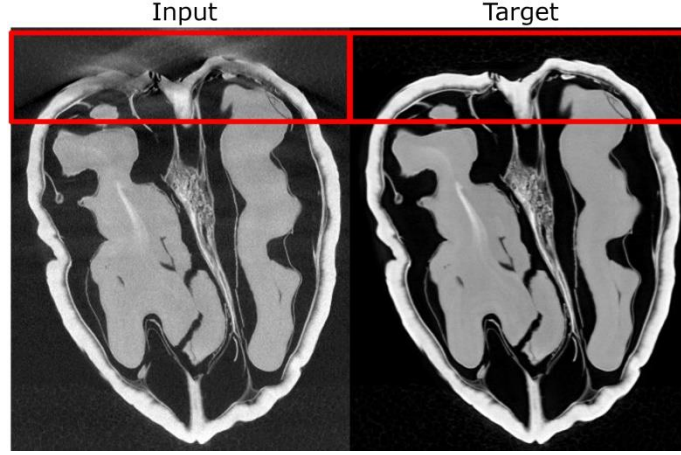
Examples of an input and target CBCT scan used to train the CNNs in this study. The red boxes indicate the regions of interest that were particularly affected by high HCAAs.
